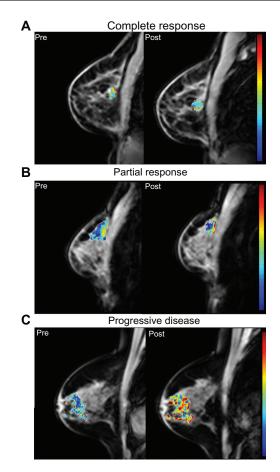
Amide proton transfer (APT) maps derived from CEST MRI in breast cancer patients undergoing NAT. Baseline (pretreatment) images are presented on the left, and images after one cycle of NAT are presented on the right. (A): patient with complete response after one cycle of therapy (27% decrease in measured APT from baseline). (B): patient with partial response (49% increase in measured APT). (C): patient with progressive disease (78% increase in measured APT). Abbreviations: CEST MRI, chemical exchange saturation transfer magnetic resonance imaging; NAT, neoadjuvant therapy.
